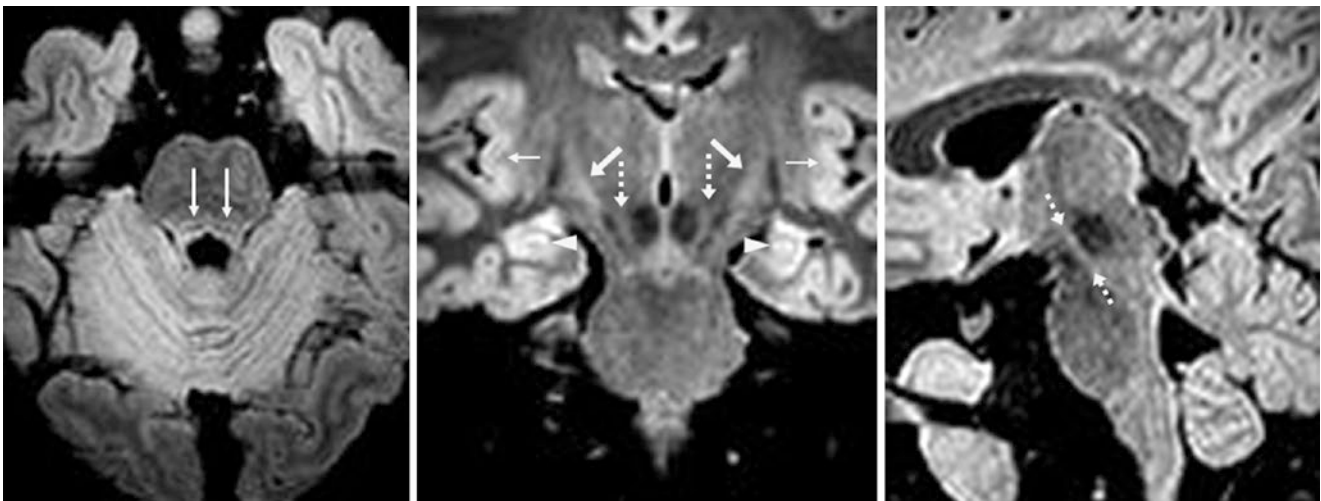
In a normal 16-year-old, axial reformats (*left*) from a 3D FLAIR at 3 T show normal, slightly bright medial lemnisci (*long arrows*). On coronal reformats (*middle*), the CSTs (*arrows*), insulae (*thin arrows*), substantia nigra (*dotted arrows*), and hippocampi (*arrowheads*) are also bright. Sagittal reformats (*right*) also define the substantia nigra
